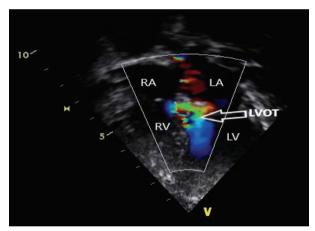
2D Color Doppler (Apical 4 Chamber) Showing Turbulence (Arrow) Across Left Ventricular Outflow due to Accessory Mitral Valve Tissue
